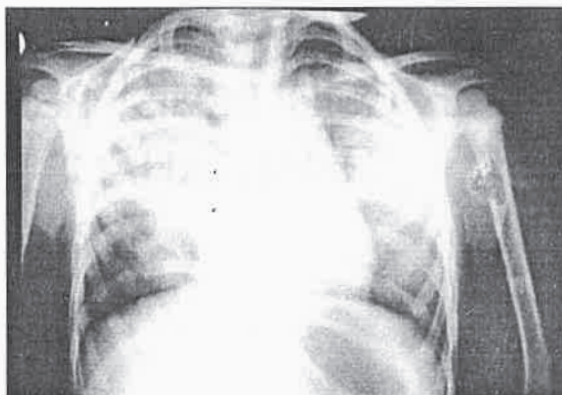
Bilateral perihilar consolidation is shown in the X-ray graphy of the thorax. Apex and basal areas are partially conserved.
